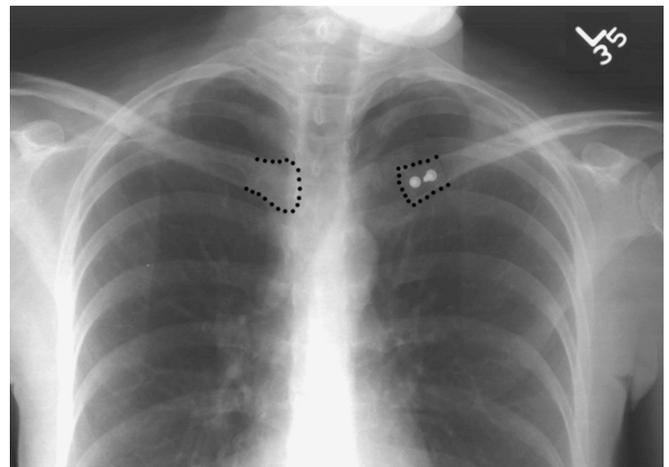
Postoperative radiograph demonstrating appropriate reduction of the left clavicle and device placement.
